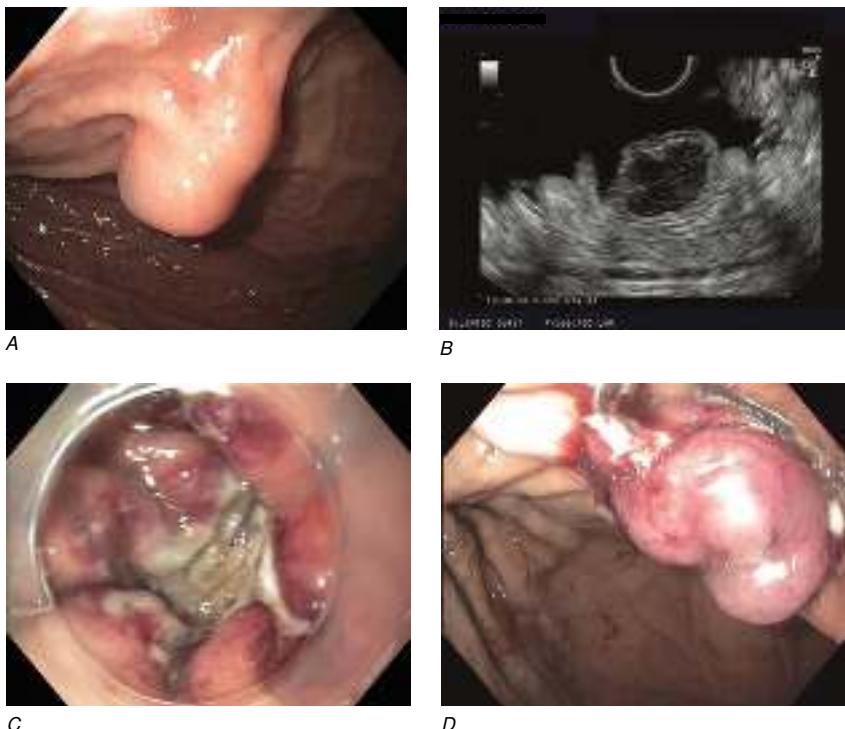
Endoscopic full-thickness resection (EFTR) of a gastrointestinal stromal tumor. *A*, Subepithelial lesion in the proximal stomach. *B*, Hypoechoic lesion arising from the fourth layer (muscularis propria) at endoscopic ultrasound. *C*, Full-thickness resection defect. *D*, Closure of defect using an over-the-scope clip.
